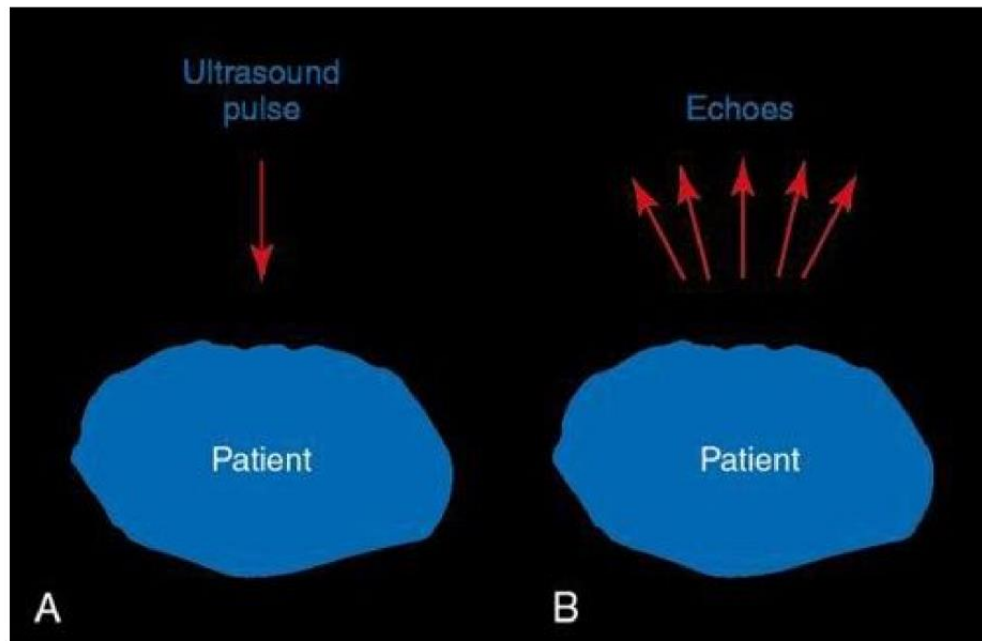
Pulse-echo technique. A, In diagnostic ultrasound, ultrasound pulses are sent into the tissues to interact with them and to obtain information about them. B, Echoes return from the tissues, providing information that enables anatomic imaging and observation of motion and flow, thus contributing to diagnosis.
